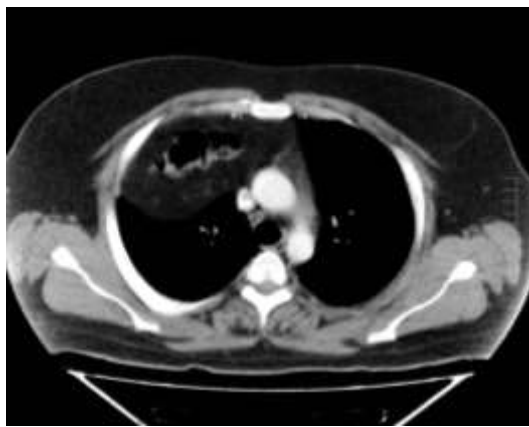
An axial CT image shows the loops of bowel and mesenteric fat herniated into the right hemithorax.
